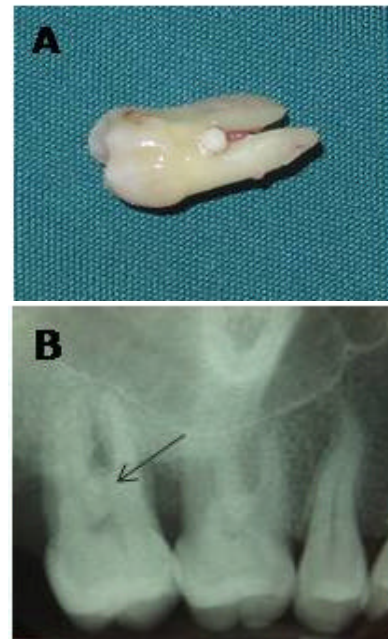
A) Enamel pearl was located adjacent the furcation between palatal and mesiobuccal roots; B) Radiographic view of the enamel pearl (arrow head)
